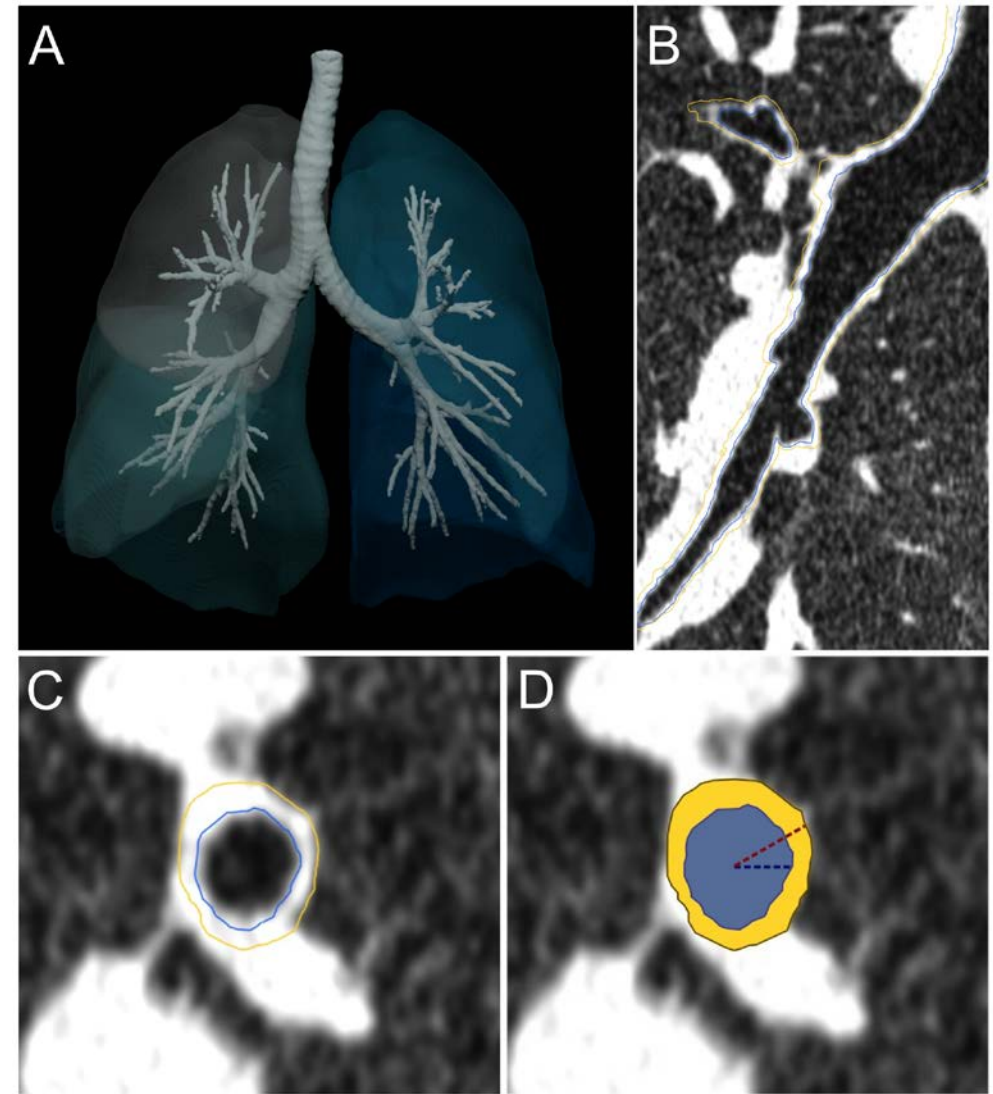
(A) Three-dimensional rendering of an exemplary airway segmentation. (B) Coronal view of a low-dose CT example of airway lumen and wall segmentation along the length of an airway (yellow outline). (C) Multiplanar reconstructed low-dose CT section perpendicular to the airway centre line demonstrates the airway lumen (blue outline) and wall (yellow outline) segmentation boundaries. (D) Example measurements of lumen radius (blue dashed line) and total radius (red dashed line). These measurements are obtained every 0.5 mm along the centre line of the airway. They are used to calculate the rest of the bronchial parameters: the luminal area (blue region) and wall area (yellow region).
